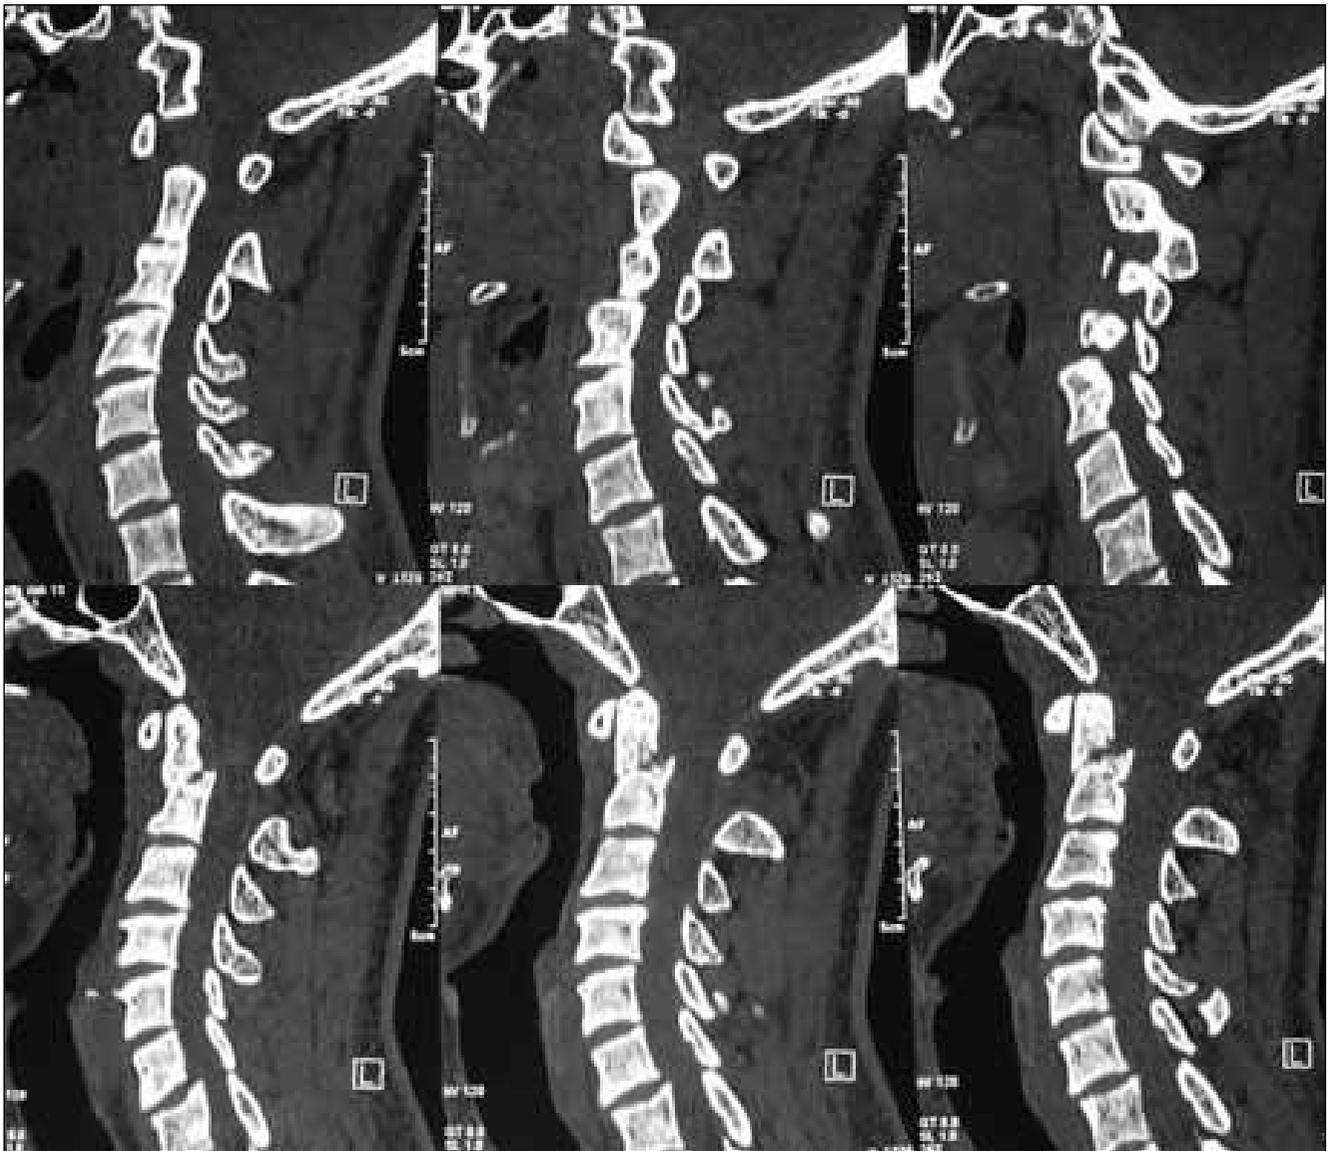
Sagittal cervical spine CT reconstruction showing Type II odontoid fracture.
